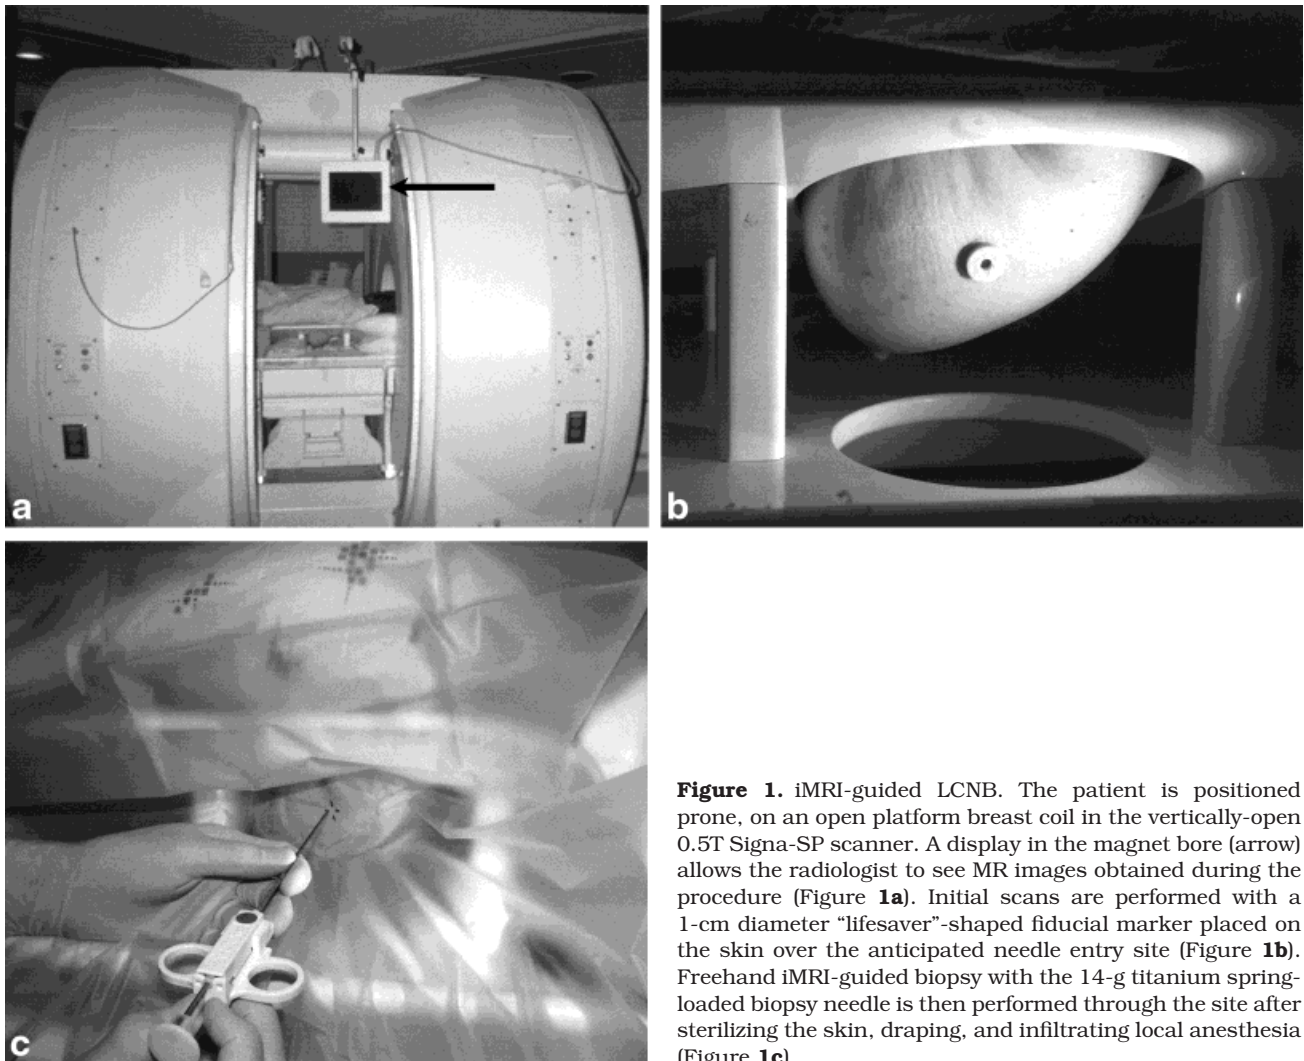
iMRI-guided LCNB. The patient is positioned prone, on an open platform breast coil in the vertically-open 0.5T Signa-SP scanner. A display in the magnet bore (arrow) allows the radiologist to see MR images obtained during the procedure (Figure 1a). Initial scans are performed with a 1-cm diameter “lifesaver”-shaped fiducial marker placed on the skin over the anticipated needle entry site (Figure 1b). Freehand iMRI-guided biopsy with the 14-g titanium spring-loaded biopsy needle is then performed through the site after sterilizing the skin, draping, and infiltrating local anesthesia (Figure 1c).
